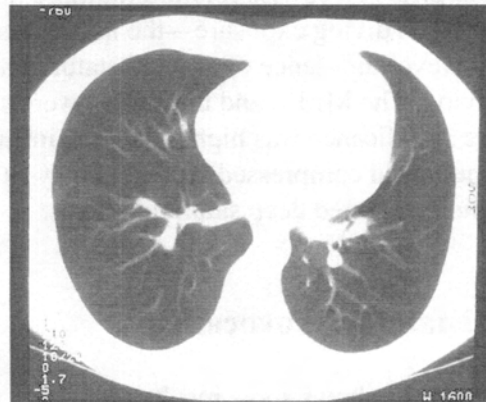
Chest CT of a diver, showing trapped air.
